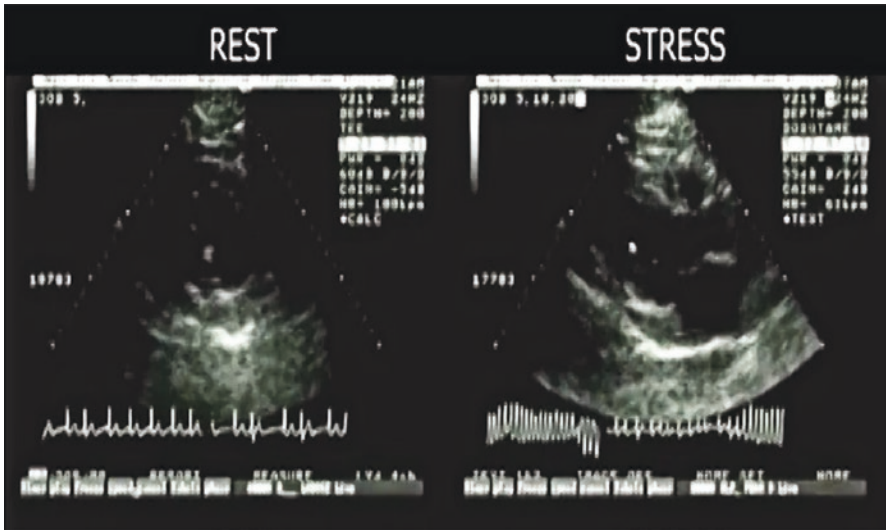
Parasternal short axis (left, resting conditions) and long-axis (right, dobutamine 20 $\mu\text{g}/\text{kg}/\text{min}$) views of a patient with frequent ventricular ectopic beats suddenly evolving in torsade de point simultaneously with the development of septal akinesis. See the corresponding Video 18.7. (By courtesy of Dr. Rafael Payà, Valencia, Spain. The video is available under the chapter's "Supplementary Material" on Springer Link)
